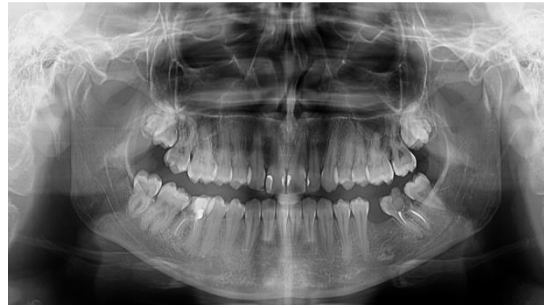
The orthopantomography
